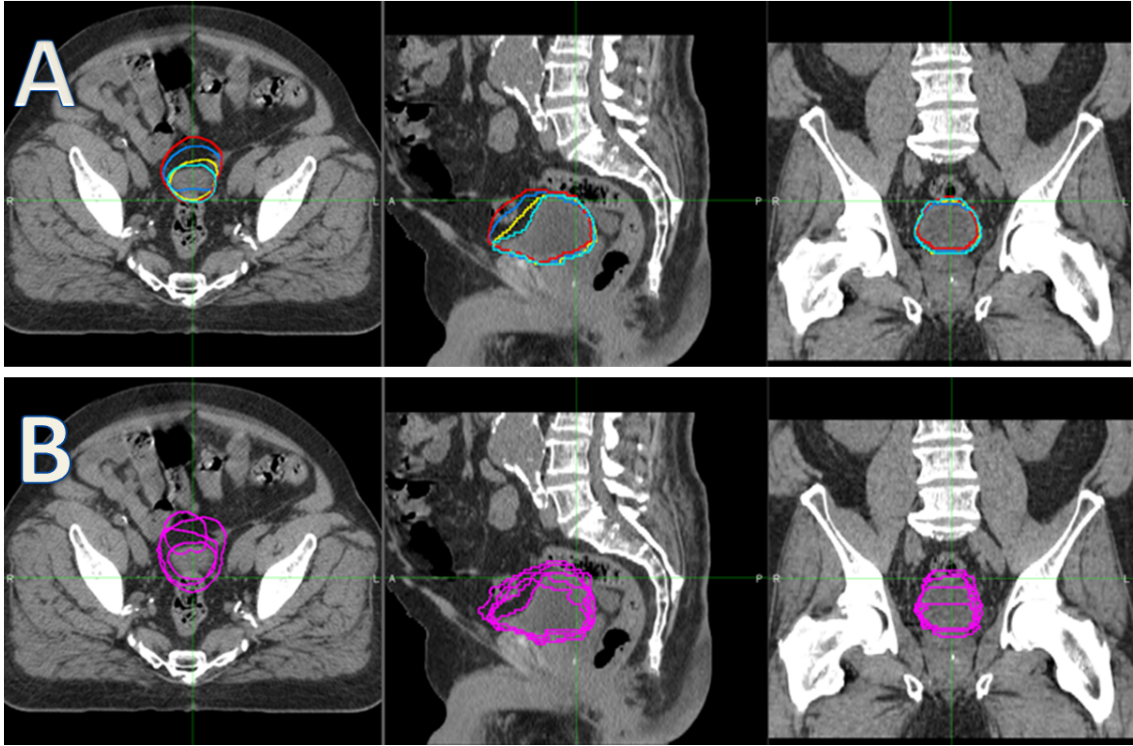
The ideas behind the Helsinki (A) and Aarhus (B) methods. In the Helsinki method (A), the objective is to catch the individual bladder filling pattern of the patient. Repeat CT images are acquired every 15 minutes, starting from the empty bladder (cyan) and stopping after 45 minutes (red). The bladder contours in these images are used as a starting point when producing the planning target volume. In the Aarhus method (B), the bladder contour of the planning CT image is combined with four CBCT scans acquired on consecutive treatment days of the first week of treatment to produce the starting point for the PTV formation. The aim of the Aarhus method is to catch changes in the bladder form and position over time.
